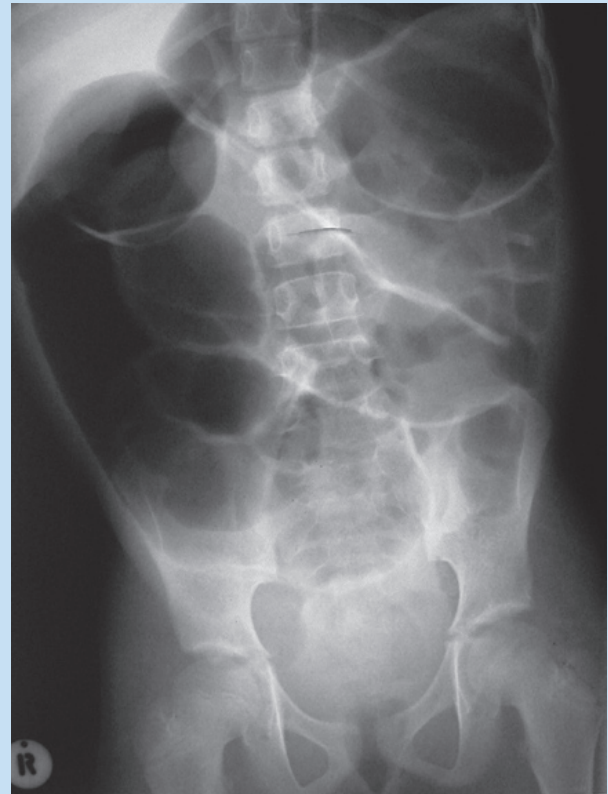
Abdominal X-ray of 9-year-old Sotho girl.
